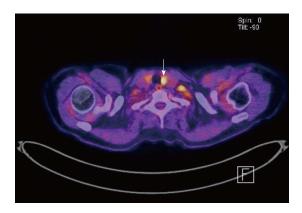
Positron emission tomography-computed tomography scan with ¹⁸F-FDG, 2016 February. Arrow: Left thyroid lobe with metabolic active node.
